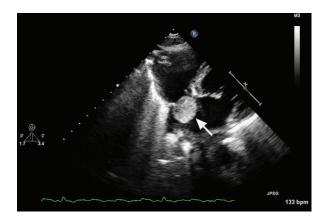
A) Transthoracic echocardiogram (subcostal view) shows a left atrial mass (arrow) arising from the interatrial septum, suspicious for myxoma. B) Photograph from autopsy shows a left atrial myxoma with a polyploid gelatinous appearance (white arrow), and a broad-based stalk attached to the interatrial septum (black arrow).
